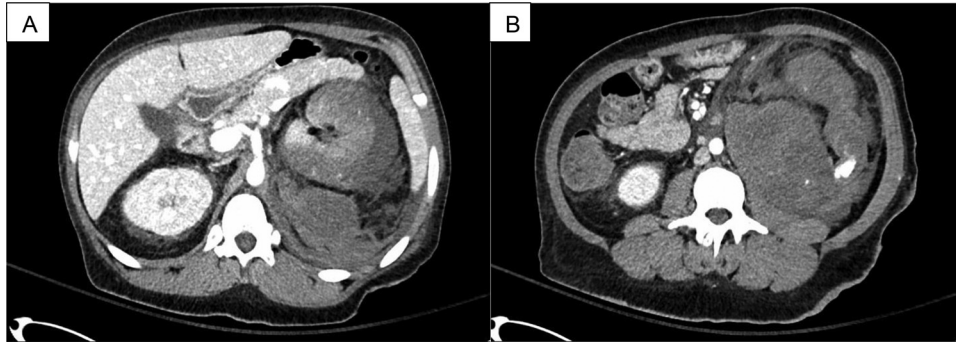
Computed tomography demonstrates (A) left subcapsular renal hematoma and (B) large retroperitoneal hematoma.
